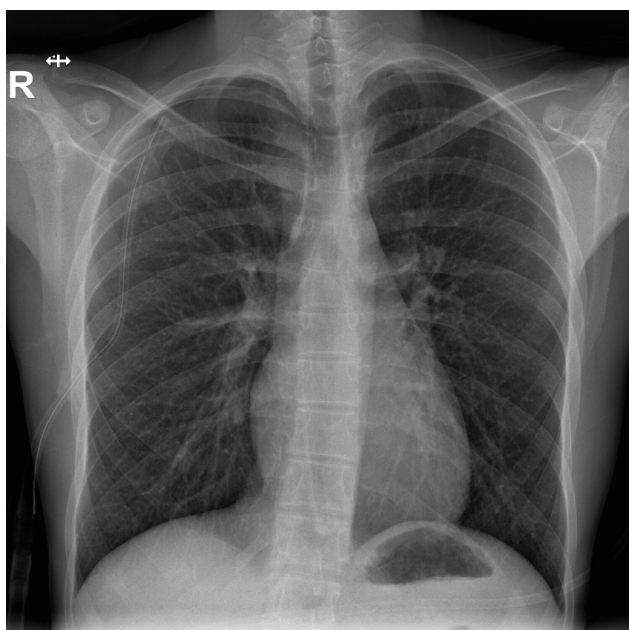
Posteroanterior chest radiograph after a thoracic drain with an almost complete lung expansion.
